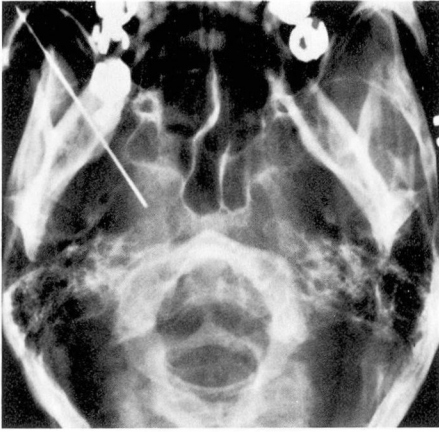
Base view roentgenogram of the electrode position.
